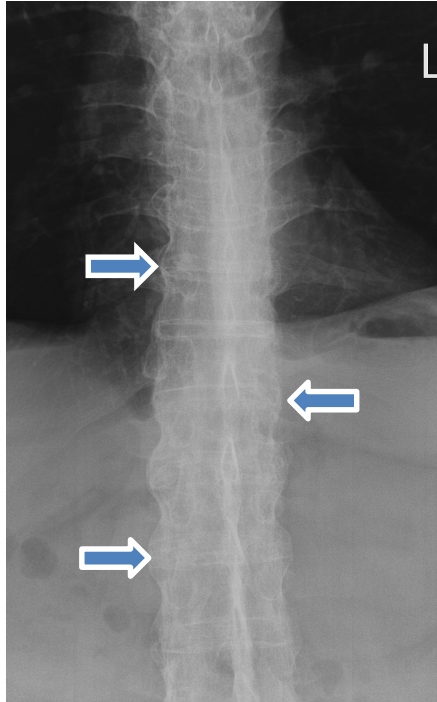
Anteroposterior lower thoracic/upper lumbar radiograph demonstrating multiple levels of thin bridging syndesmophytes at the right and left lateral disc margins (bamboo spine, arrows).
